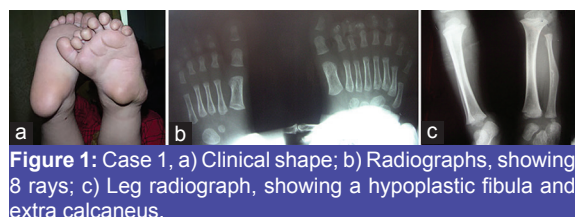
Case 1, a) Clinical shape; b) Radiographs, showing 8 rays; c) Leg radiograph, showing a hypoplastic fibula and extra calcaneus.
